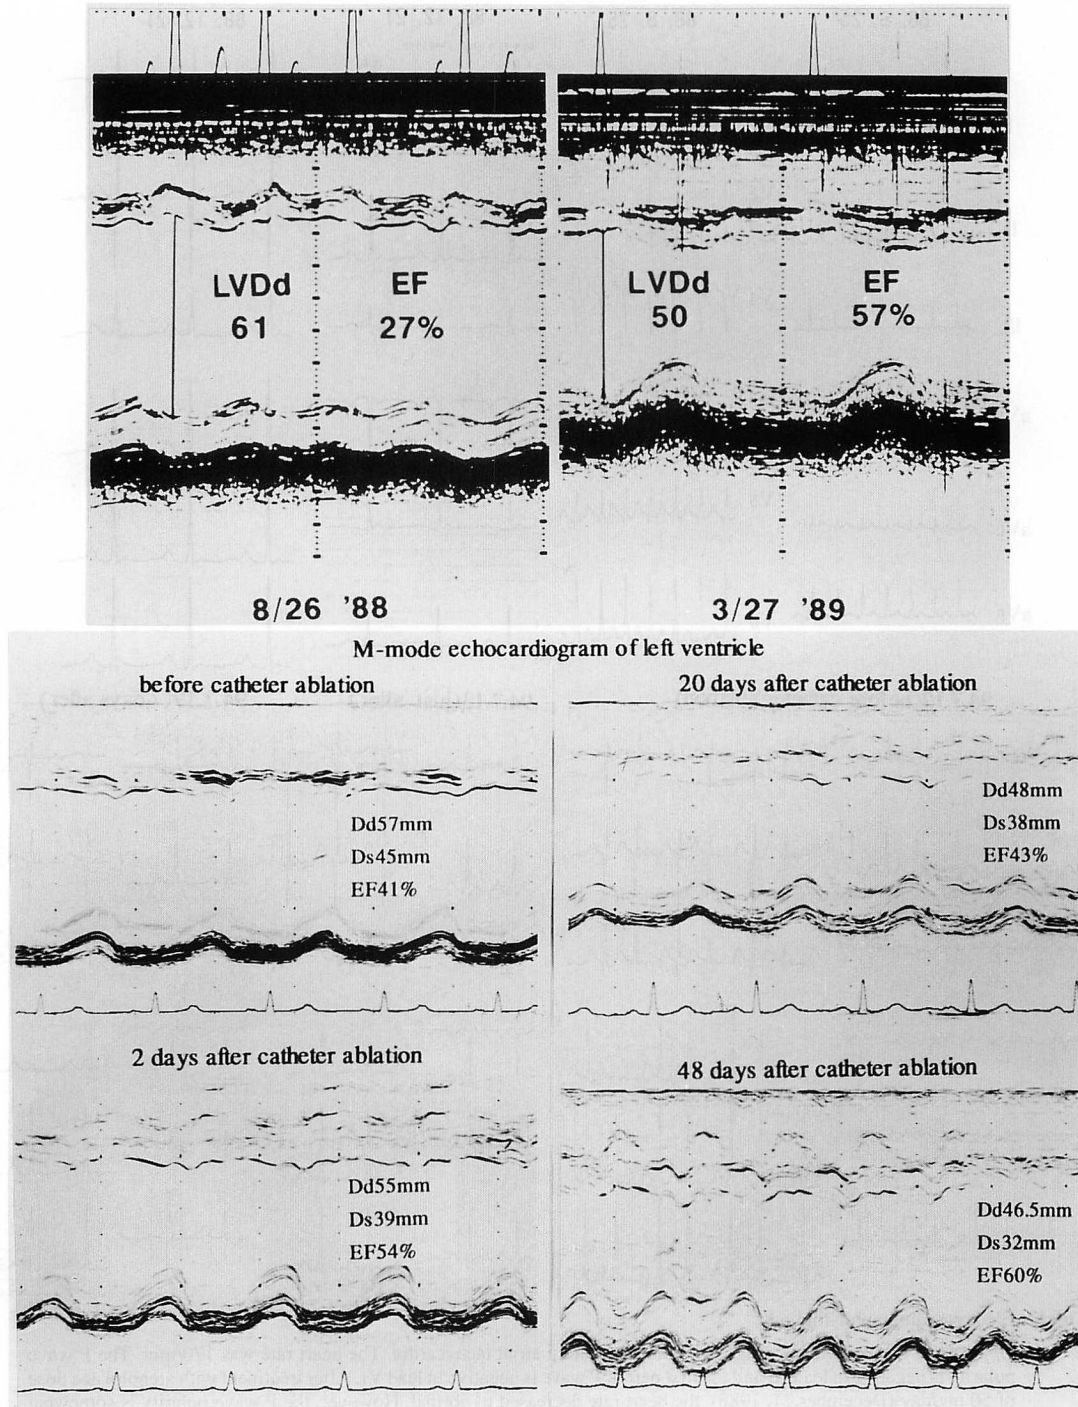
Echocardiographic findings
